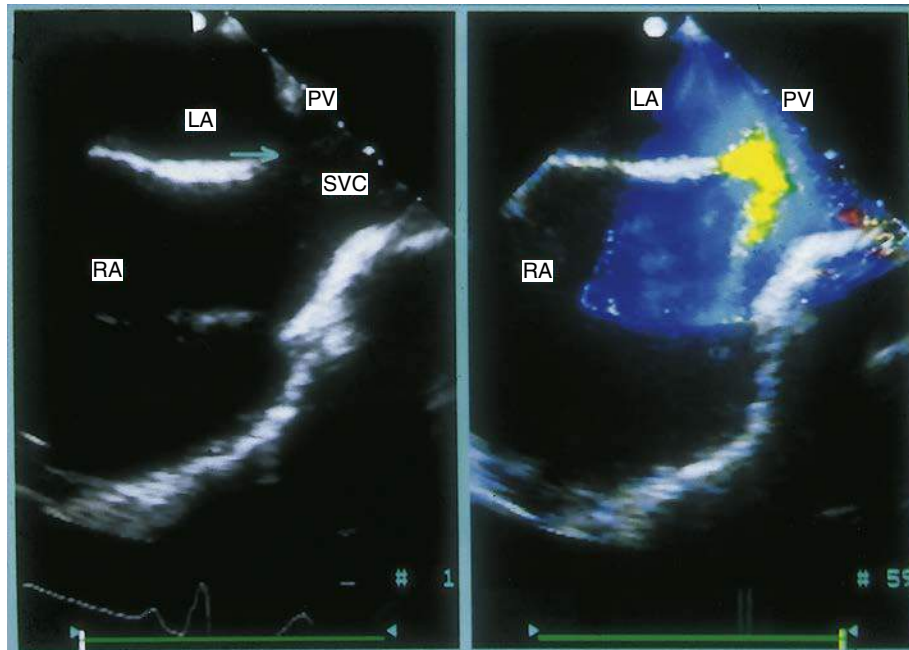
Vertical section from a transesophageal echocardiogram of a superior sinus venus defect (arrow) in which the superior vena cava (SVC) overrides the atrial septum and therefore connects to both the left atrium (LA) and right atrium (RA). The right upper pulmonary vein (PV) connects to the SVC. The right panel reveals the left-to-right shunt demonstrated by color flow Doppler imaging.
